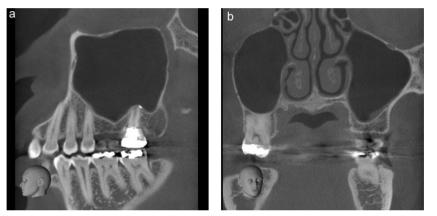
Preoperative cone-beam computed tomography images. 2a Sagittal view. 2b Coronal view.
